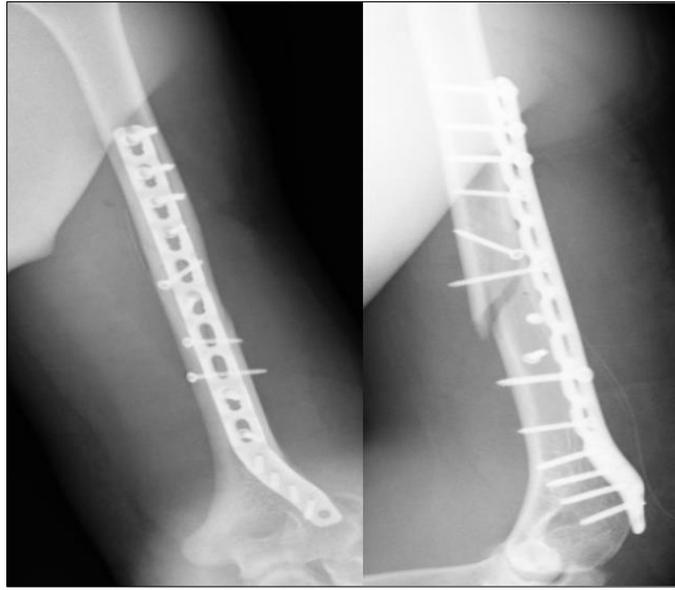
Postoperative radiograph at 40 weeks of follow up showing complete radiological union
